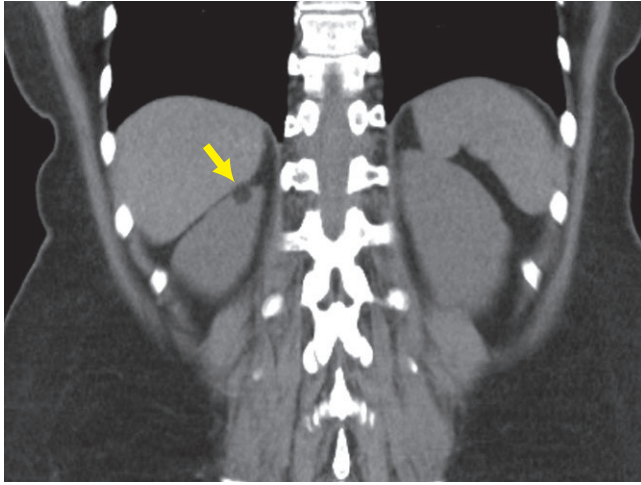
Reconstructed CT scan of the abdomen shows a well-demarcated mass (arrow) in the upper pole of the right kidney. Hounsfield units of this mass were -55.
